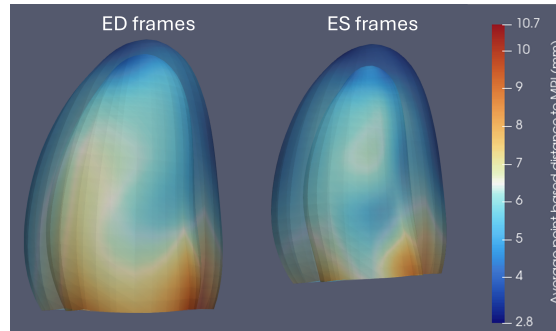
Average point based alignment between LV models generated from 2DE and MRI (N=38). The side with the largest average point-based distances is shown.
